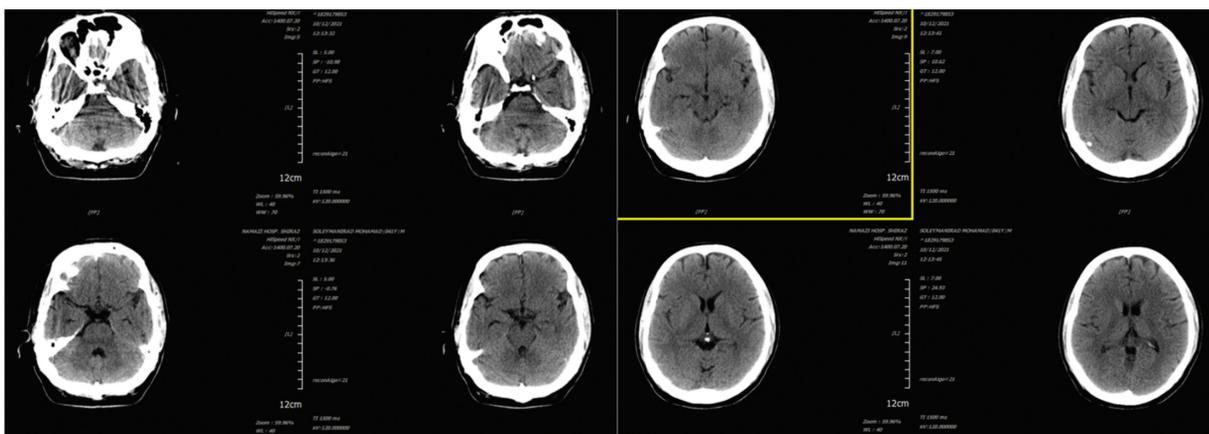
Axial noncontrast brain computed tomography showing obliteration of the basal cisterna and narrowed sulcal spaces, which is suggestive of brain edema and in favor of PTC.
